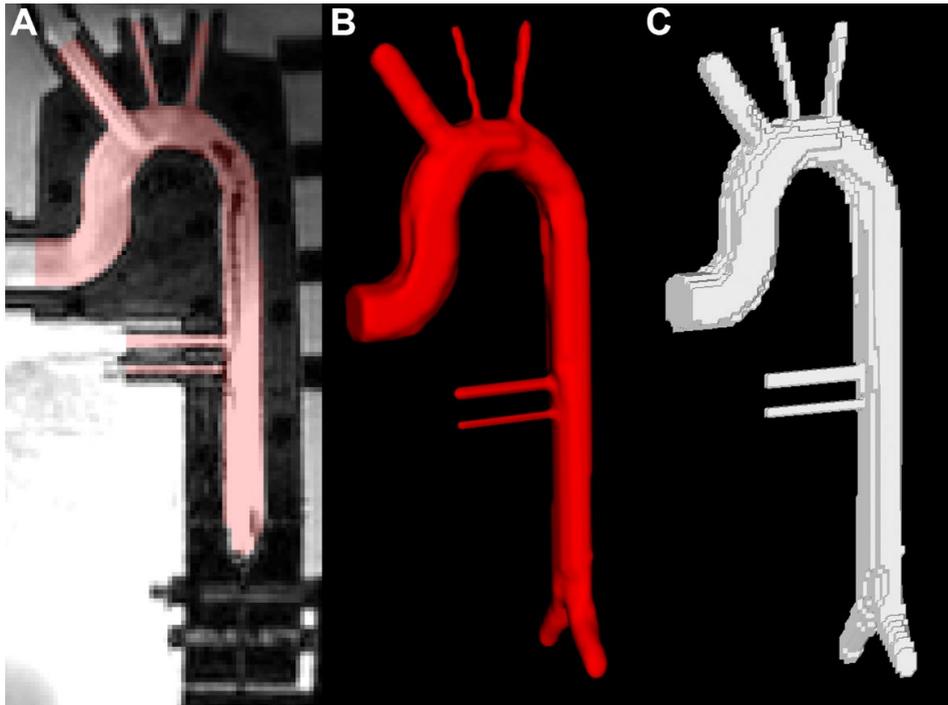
Process of 4D flow MRI to 3-dimensional geometry, the image to geometry (A-B), the geometry to visualization (C).
